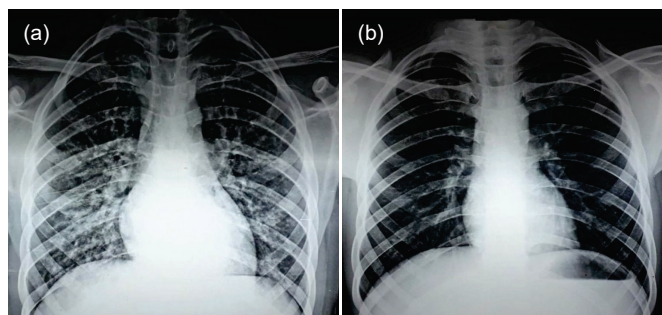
Chest X-ray showing (a) infiltrates in bilateral lung fields during hospitalization and (b) normal lung fields after treatment.
